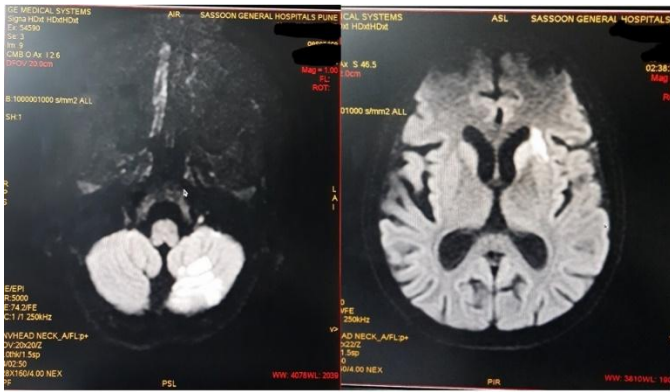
DWI images showing diffusion restriction in left cerebellar hemisphere and left basal ganglia s/o vasculitic infarcts.
